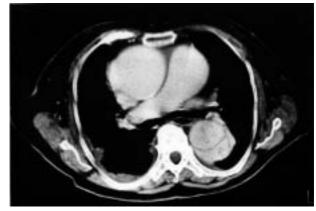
Computed tomographic scan, showing a right chylothorax (after pleural drainage) in association with an ascending aortic aneurysm and dissection of the descending aorta.
